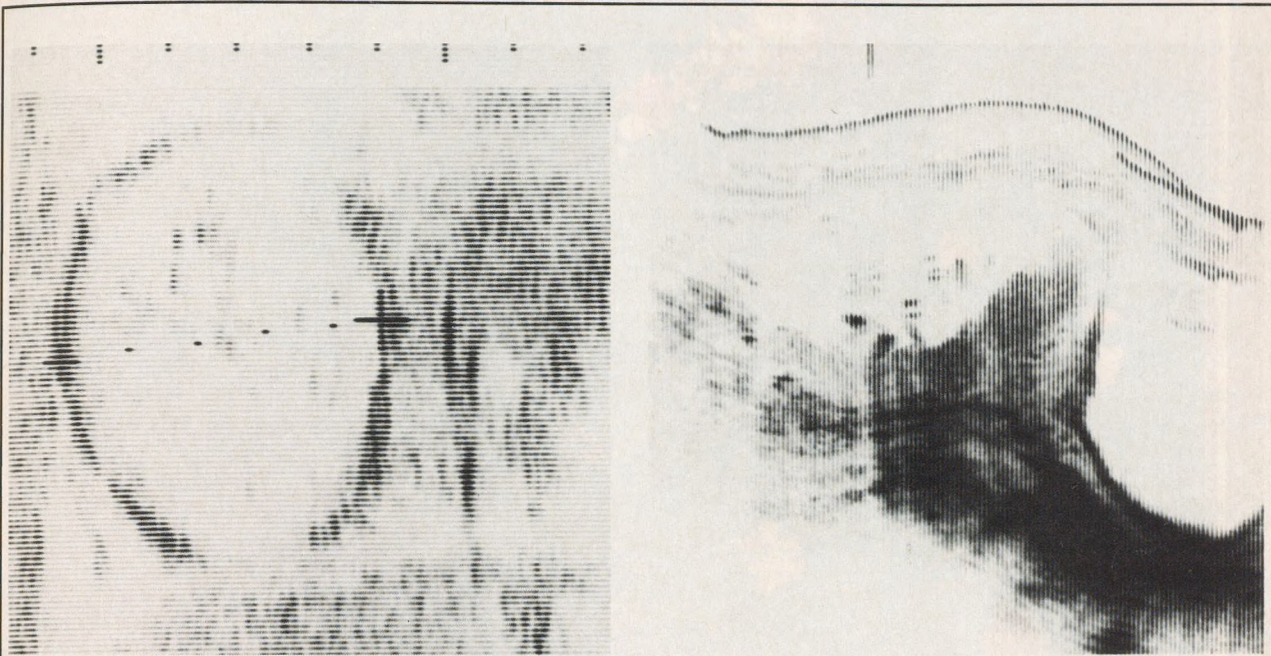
Ultrasound of the fetus obtained at 20 weeks' gestation. Biparietal diameter of 4.7 cm corresponds to 20.4 weeks \pm 1.6 (left). Bladder, fetal head, and placenta can be seen in transverse view of abdomen (right)
